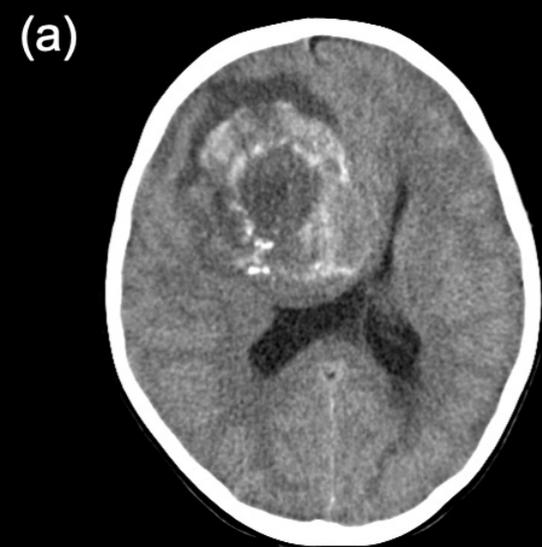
Radiological images. (a) Head computed tomography showing a right frontal lobe tumor with a high density region suggesting intratumoral calcification. (b) T1-weighted magnetic resonance imaging (MRI) showing a low-intensity tumor. The presence of subacute hemorrhage was also suggested by an intratumoral high intensity region. (c) T2-weighted MRI showing a mixed high intensity tumor. (d) Gadolinium-enhanced T1-weighted imaging showing enhancement of the tumor. (e) Gadolinium-enhanced T1-weighted imaging taken on the day after surgery showing no evidence of the tumor. (f) Fluid attenuated inversion recovery imaging 3 months after surgery showing local recurrence of the tumor.
